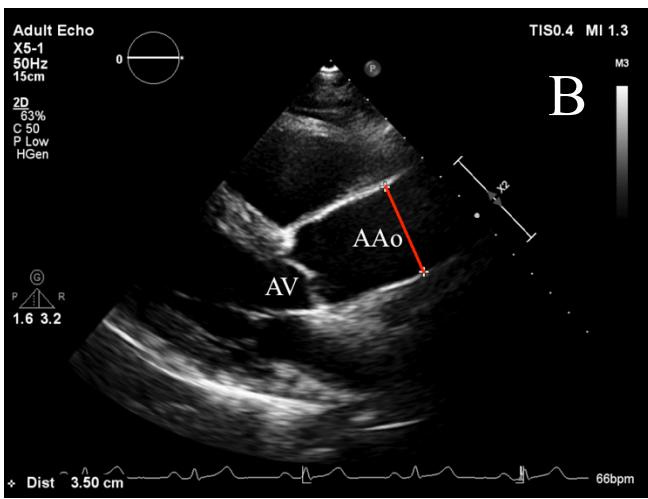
A) Non-contrast CT-scan with anterior-posterior measurement of the ascending aortic (AAo) diameter on the first circular level above the sinotubular junction from exterior-to-exterior surface. B) Transthoracic echocardiography measurement of the ascending aortic (AAo) diameter from inner-edge to inner-edge in the parasternal long-axis view with the aortic valve (AV) as reference point. C) Transthoracic echocardiography of the AAo from inner-edge to inner-edge in the parasternal long-axis view, one intercostal space higher than (B)
